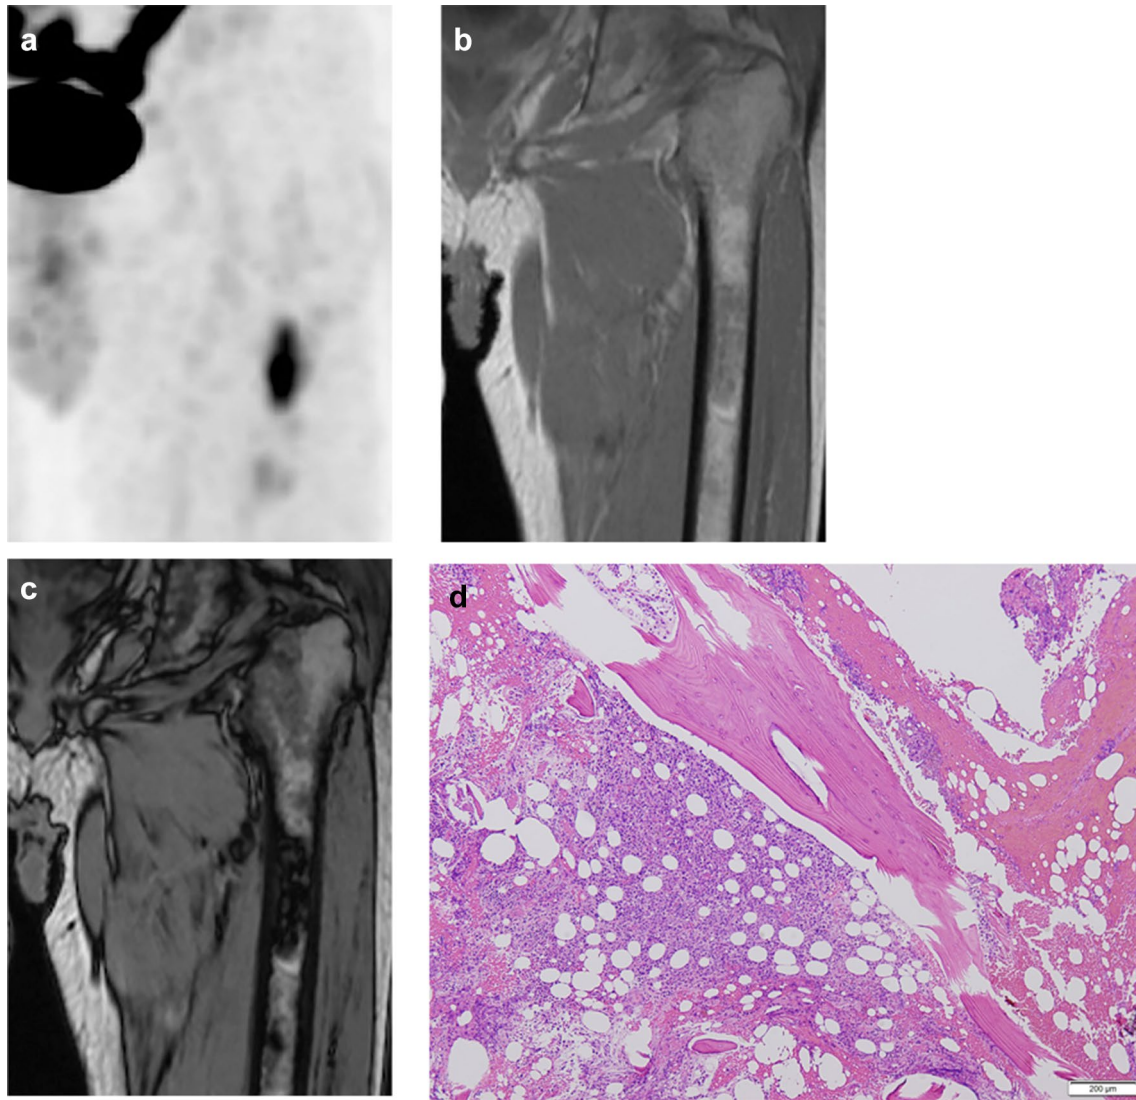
A 65-year-old male patient with a history of malignant lymphoma in clinical remission. Maximum intensity projection of FDG-PET CT image a shows a focal hot spot in the left femur. SUV_{max} of the lesion is 7.7, which is high enough to suggest metastasis. Coronal in-phase b demonstrates a signal intensity of 300.1 whilst the opposed-phase c shows a signal intensity of 53.8. Signal change ratio
